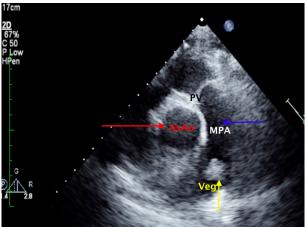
Parasternal short axis transthoracic echocardiogram at the level of the pulmonary valve showing the vegetation (yellow arrow; Veg) within the main pulmonary artery (blue arrow; MPA) beside the ascending aorta (red arrow; AsAo)
